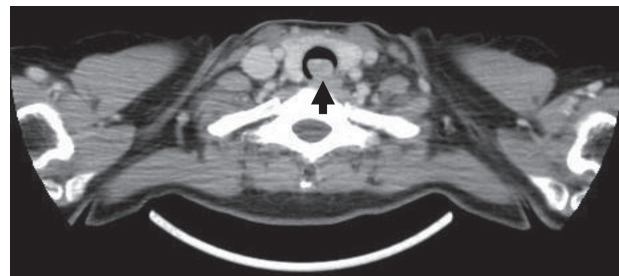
Chest CT findings demonstrated a round tumor arising from the membranous portion of the trachea (arrow).
